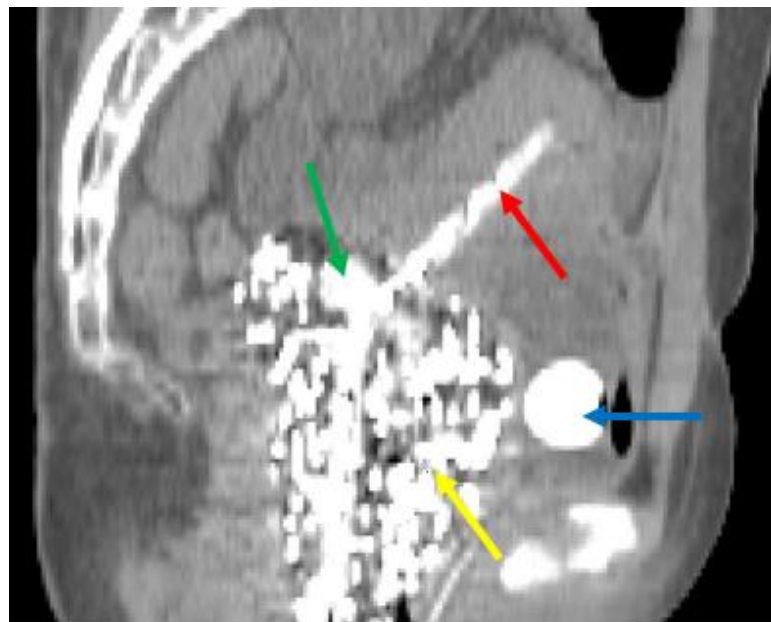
Sagittal CT of intrauterine tube (red arrow) and ring (green arrow) positioned for brachytherapy with packing in vagina (yellow arrow) and urinary catheter balloon (blue arrow)
